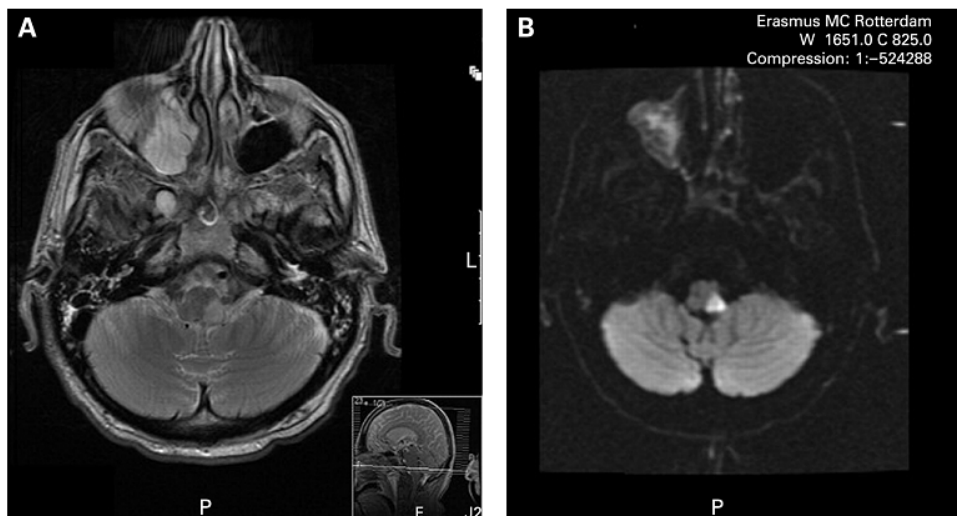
MRI scan of patient during second episode.
